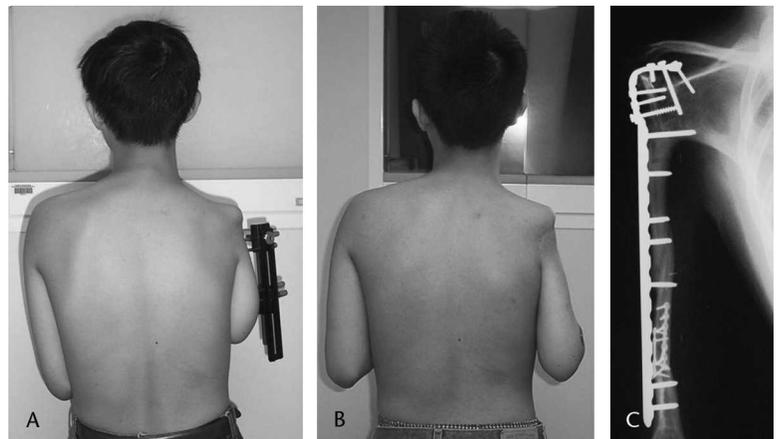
Photographs show (A) the patient's LLD before lengthening and (B) after lengthening. (C) A radiograph shows the patient's right humerus 6 months after ORIF for the regenerate fracture.
